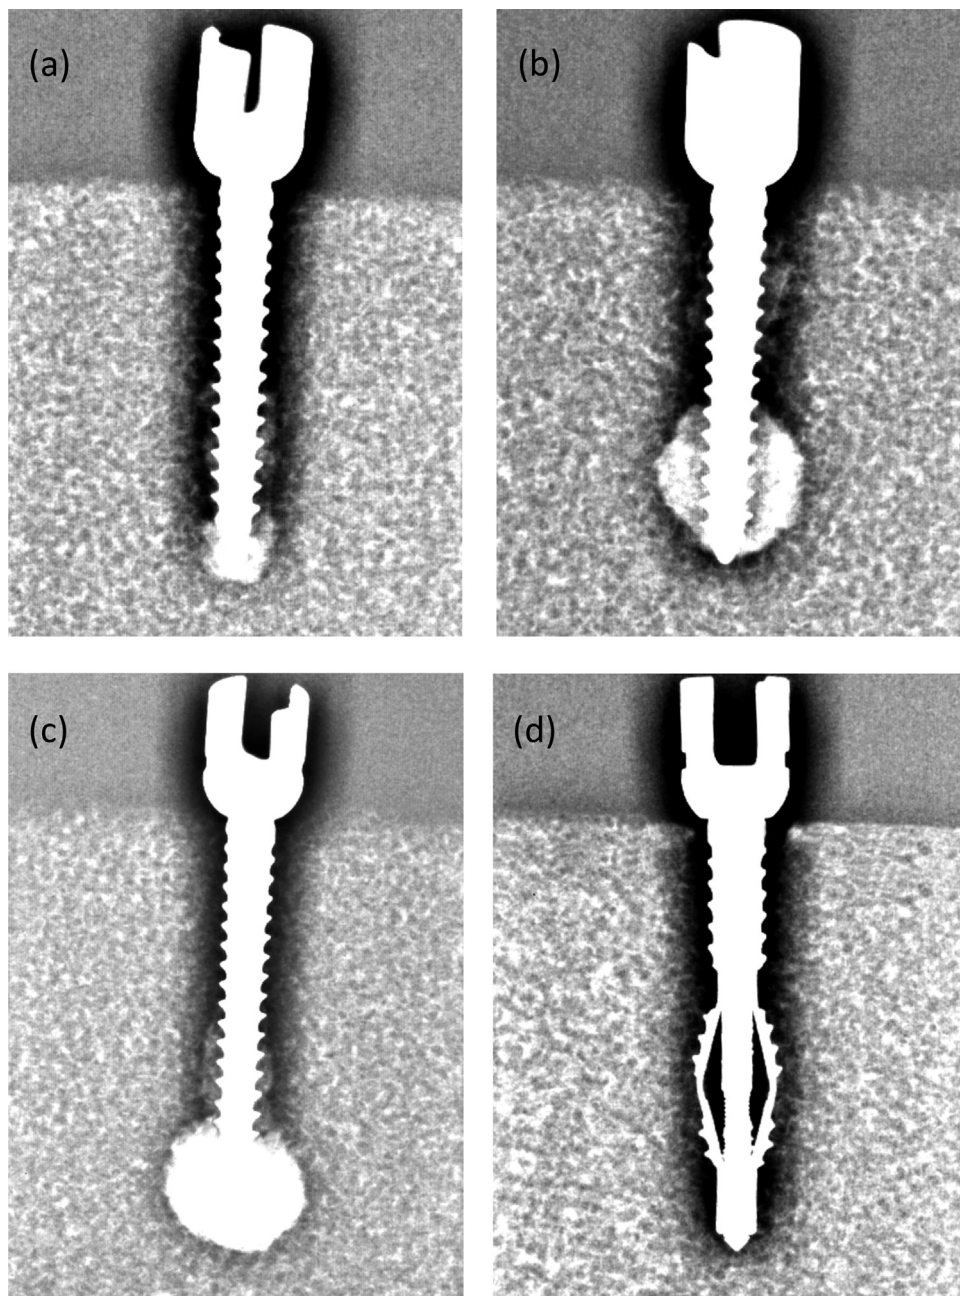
The radiographic images of conventional pedicle screw augmented with bone cement volume of (a) 1 ml, (b) 2 ml, (c) 3 ml, and the expandable screw ($\Phi 6.5$ mm, length 50 mm).
